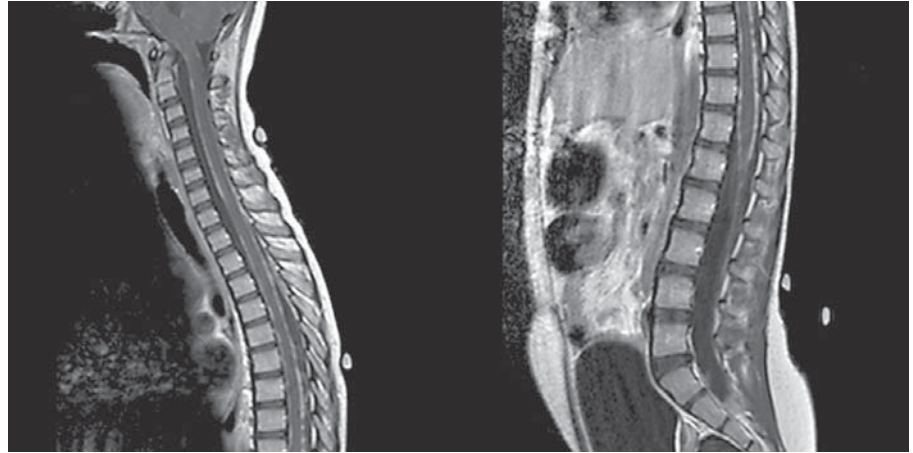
MRI of the spine. Diffuse dural enhancement throughout all segments.
